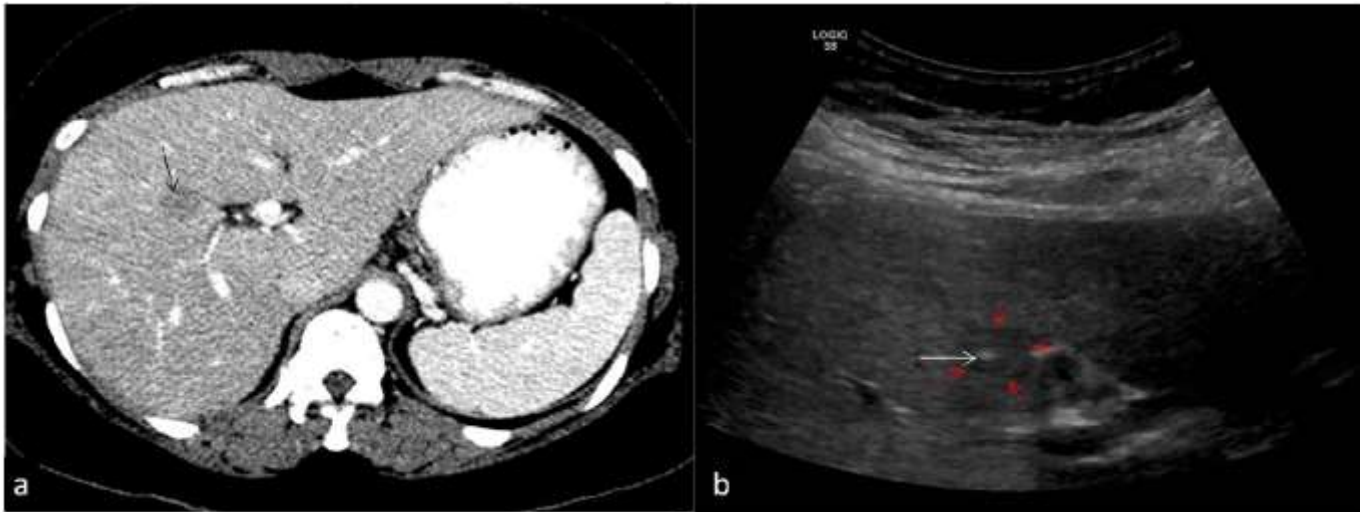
46 Y/ Female patient, treated case of carcinoma rectum (post NACT-RT, post exenteration). She developed new onset 14 mm liver lesion on surveillance CT scan, 9 months after the surgery and also appeared metastatic on CT scan (arrow in a). USG guided FNAC was done from the liver lesion (red arrow in b denotes liver lesions and white arrow denotes tip of spinal needle in the lesion). Cytology report was suggestive of bile duct adenoma, which is a benign lesion.
